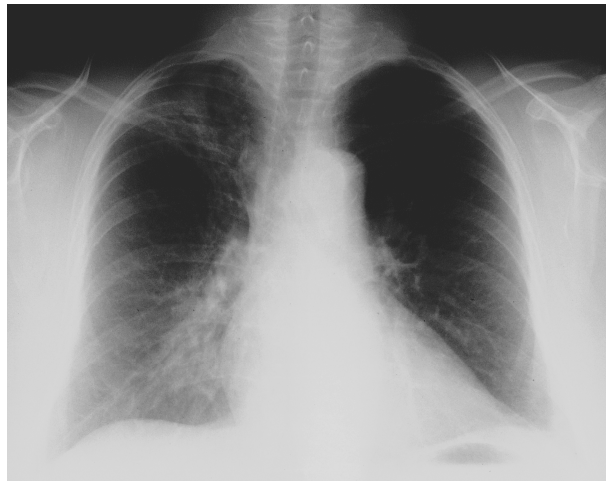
3. Example of grade 2 abnormalities in all 3 regions of the right lung on chest X-ray.
